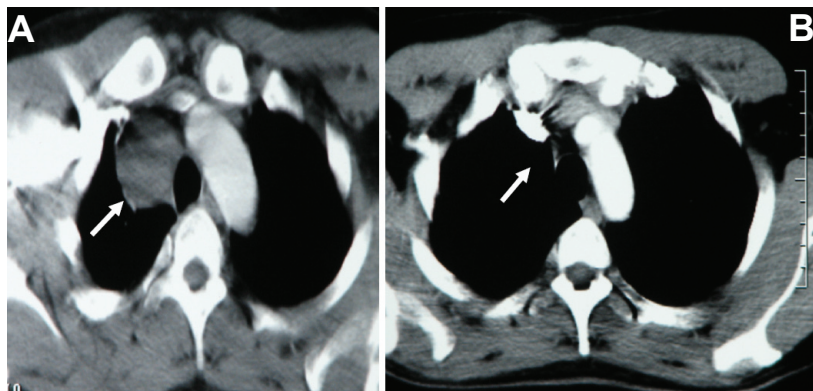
Chest CT at diagnosis, showing mediastinal tumor (A), and after three cycles of chemotherapy (B)
